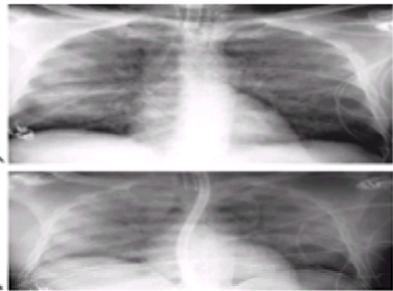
Salt-water near-drowning. (a) Portable anteroposterior chest radiograph within 1 hr after presentation. Chest film shows extensive confluent perihilar density in the right and left lungs. Note sparing of subpleural areas at the periphery and at both bases. (b) Twelve hours later. Note progression of lung infiltrates throughout both lungs, air bronchograms, and reduced lung volumes despite gastric tube decompression.
